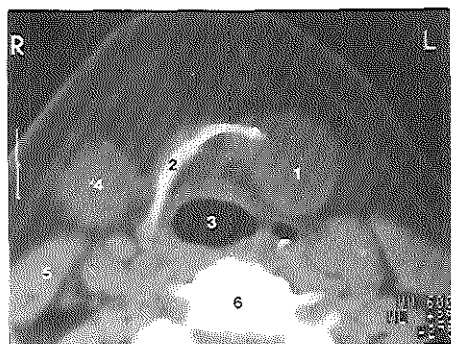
Transverse CT view at the level of the hyoid bone of the same patient. The laryngocele is clearly demonstrated as a fluid filled, encapsulated structure adjacent to the hyoid bone.
